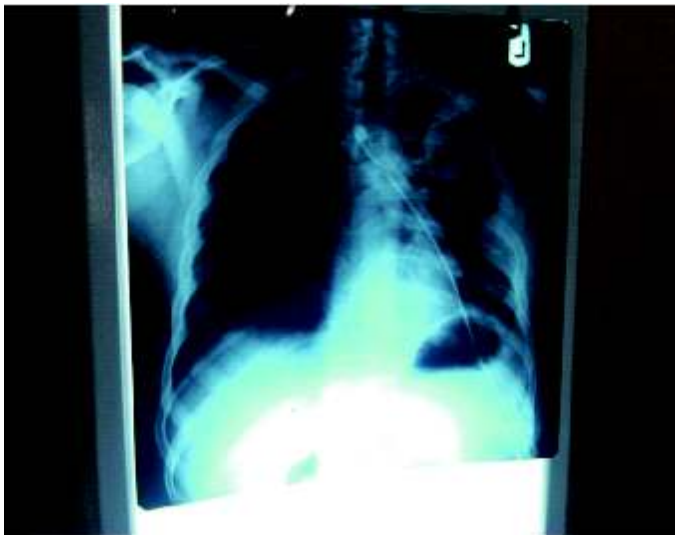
Chest Radiograph PA View before surgery showing the mass in the left hemithorax and left lung atelectasis
